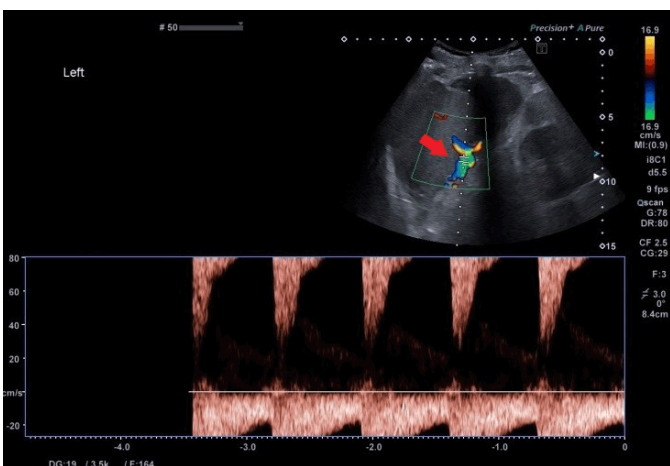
Ultrasound follow up post drainage, showing partial recanalization of portal vein respectively (red arrow).
